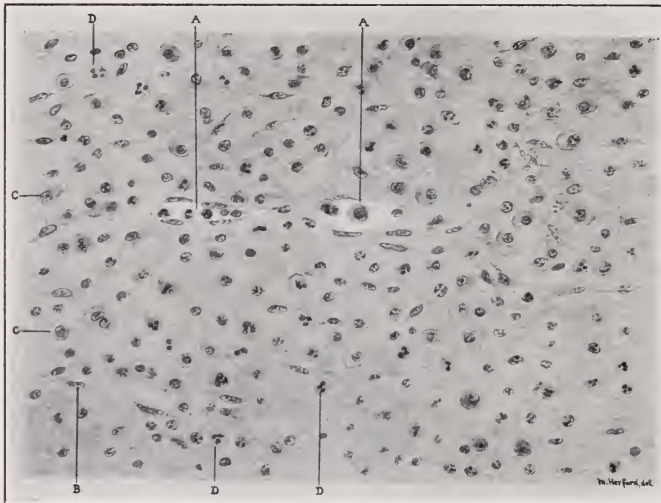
Granulation tissue of periapical infection. *a*, vessels containing lymphocytes and polymorphonuclears; *b*, fibroblasts; *c*, plasma cells; *d*, polymorphonuclears. (Thoma.)
